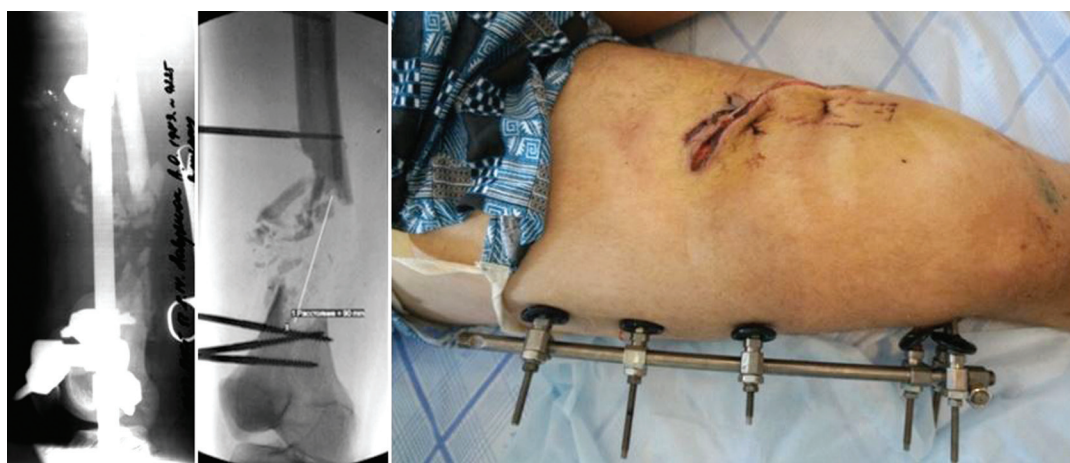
Radiographs of the femur and the appearance of the thigh upon admission
